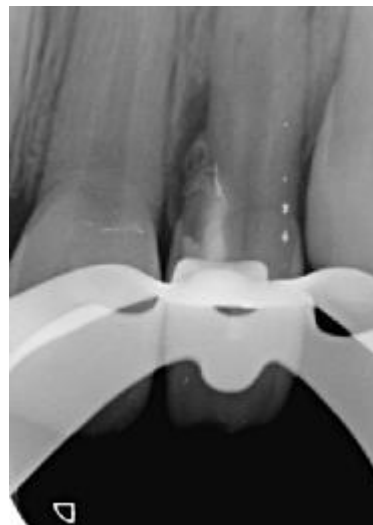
Periapical radiograph of maxillary left lateral incisor demonstrating MTA root canal filling of invaginated canal.
